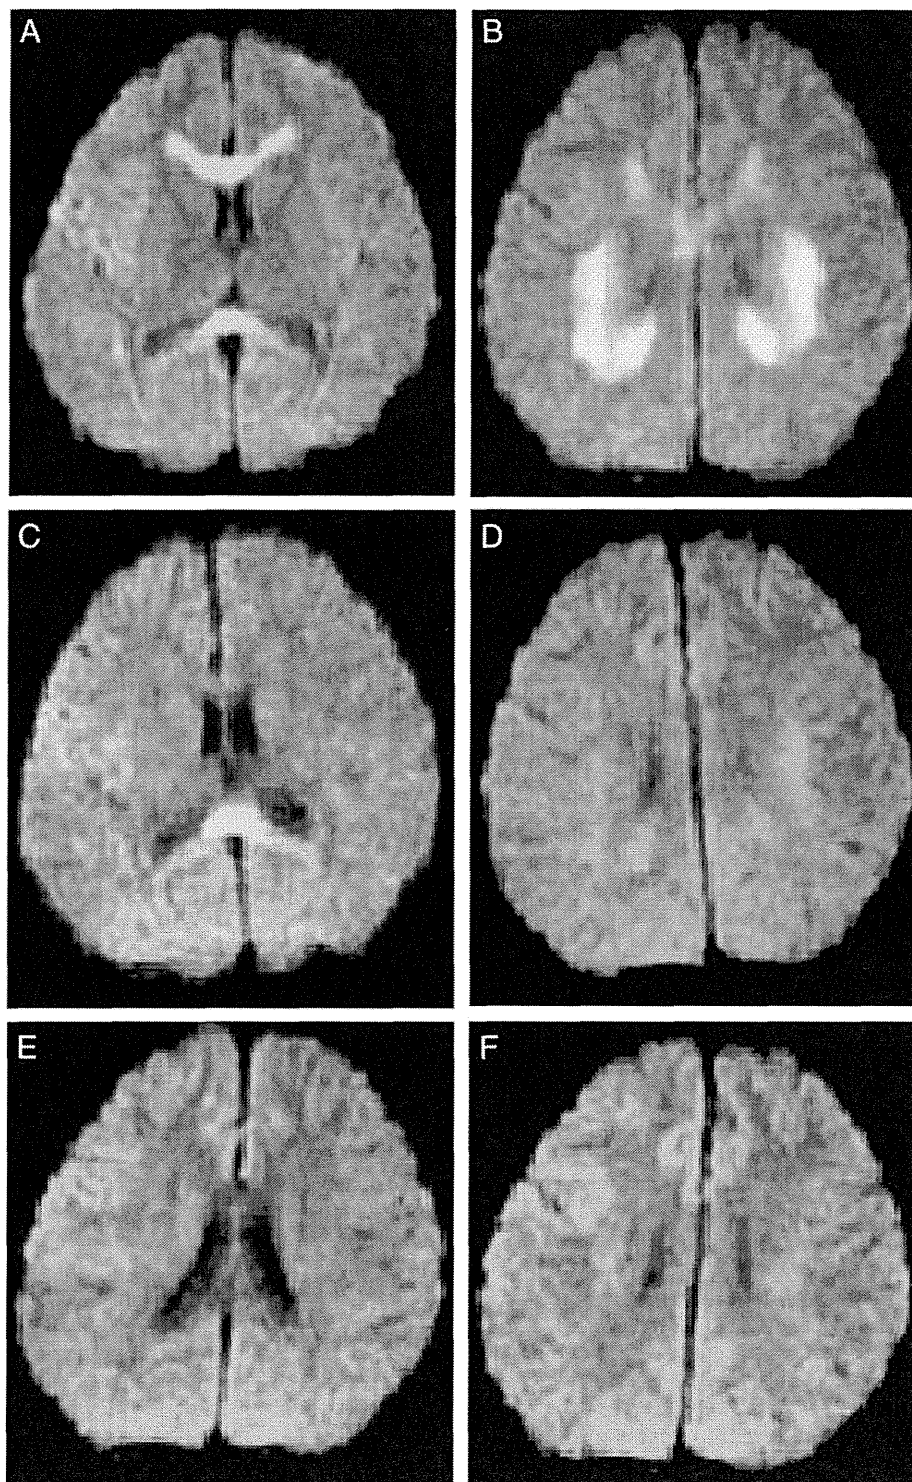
DWI on admission (day 4) showed markedly hyperintense lesions in the bilateral white matter and entire corpus callosum (A, B). Second DWI on day 5 showed a markedly hyperintense lesion in the SCC (C), but lesions in the white matter and corpus callosum other than the SCC had decreased in size and signal intensity (D). Third DWI on day 17 showed complete resolution of these lesions (E, F).
